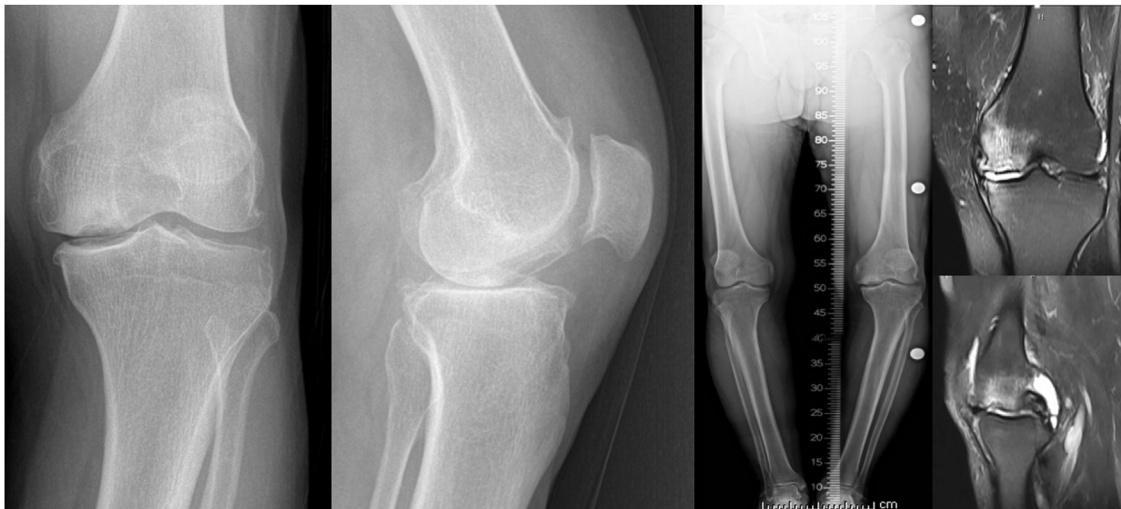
Osteonecrosis in the medial femoral condyle is prominent in the preoperative radiographs and MRI of the knee.
